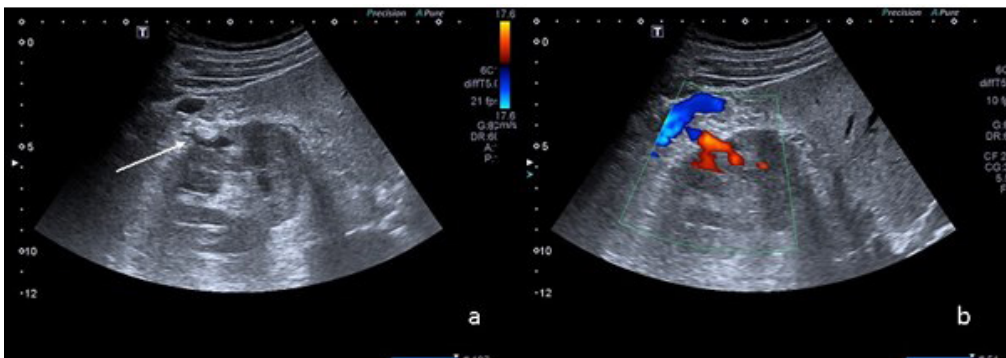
Grey-scale sonography (a) shows tortuous cystic structure (arrow) passing through the renal parenchyma and coursing in the pararenal fat space, compatible with a vessel at Doppler US (b).
